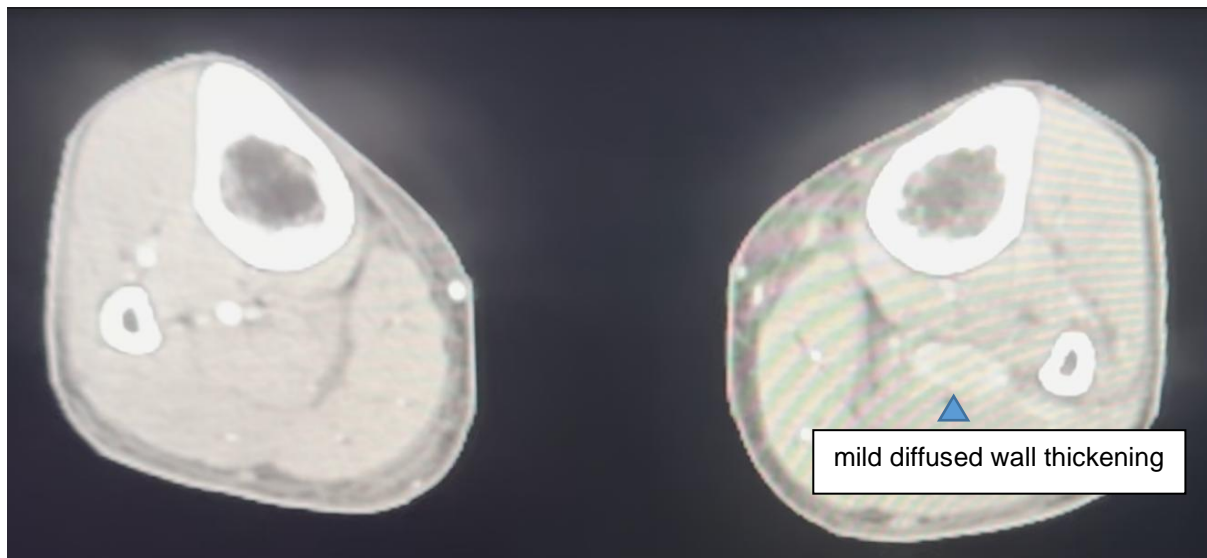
Initial CT-A revealed total occlusion along the left proximal to distal anterior tibial artery, left plantar arch with mild diffused wall thickening and adjacent perivascular fat haziness, which could be vasculitis.
